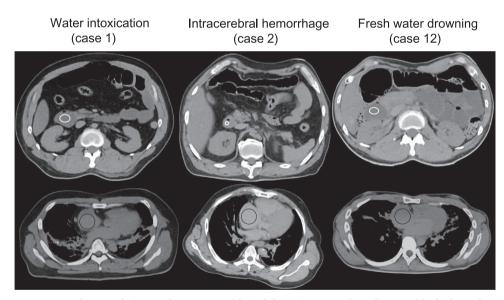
Representative postmortem computed tomography images. The attenuation of the circled areas (upper row: descending part of the duodenum, lower row: the right atrium) was measured in each case. The values of attenuation of the descending part of the duodenum were 7 HU (case 1), 39.3 HU (case 2), and 11.7 HU (case 12). The values of attenuation of the right atrium were 46 HU (case 1), 73 HU (case 2), and 45 HU (case 12).
